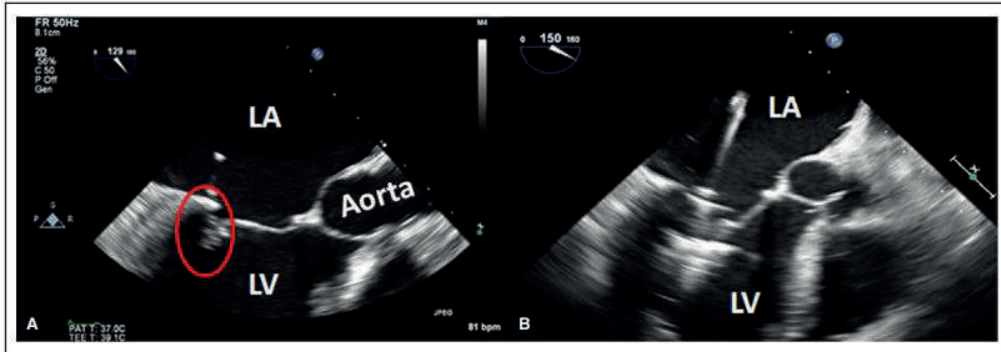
Case example in which more extreme transesophageal echocardiography angulation optimized visualization of the posterior leaflet. A, Poor visualization of the posterior leaflet with the standard transesophageal echocardiography view (indicated by the red circle). B, More extreme angulation offered better visualization of the posterior leaflet. *LA indicates left atrium; and LV, left ventricle.*
